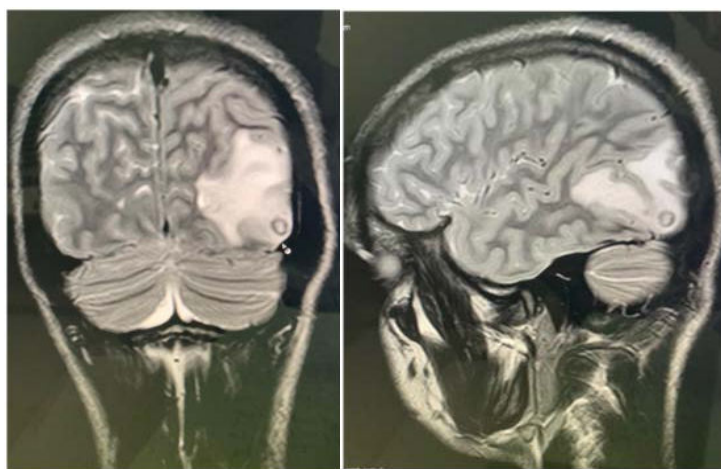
Well defined T2/FLAIR with hyperintensity with hypointense rim in left parietal region, Most likely Tuberculoma.
